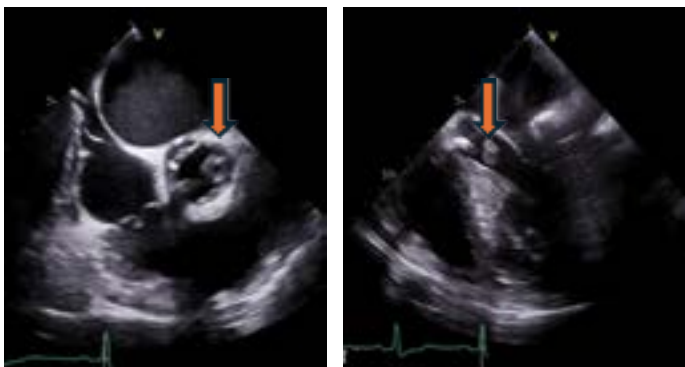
Echocardiography showing a large (1.4 x 0.7 cm) aortic valve vegetation (arrows).
